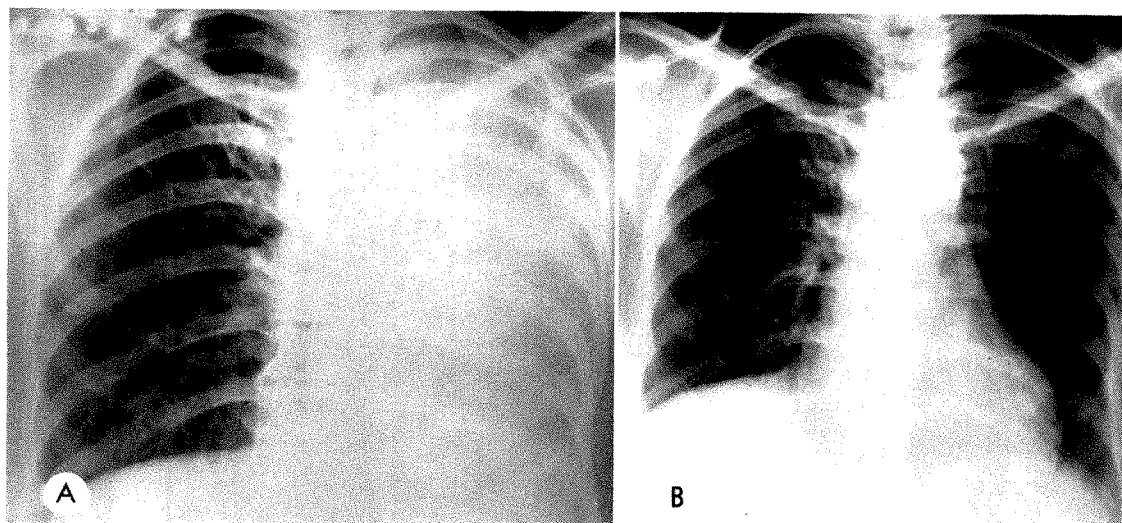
Case I. Endobronchial Hodgkin's disease. (A) Atelectasis of the left lung. (B) Complete re-expansion of the lung following roentgen therapy. (The findings were identical in Case II.)
